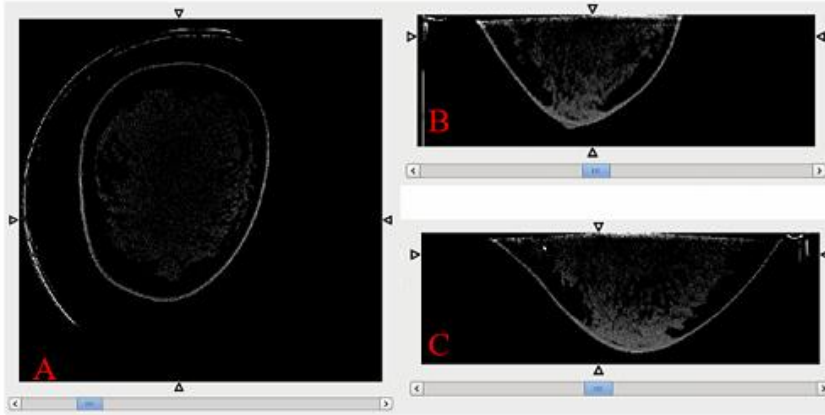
Different views of patient’s breast CT scans used in this study [49]. (A) transverse view. (B) coronal. (C) sagittal. All 512 images of patient’s breast can be viewed by scrolling through.
